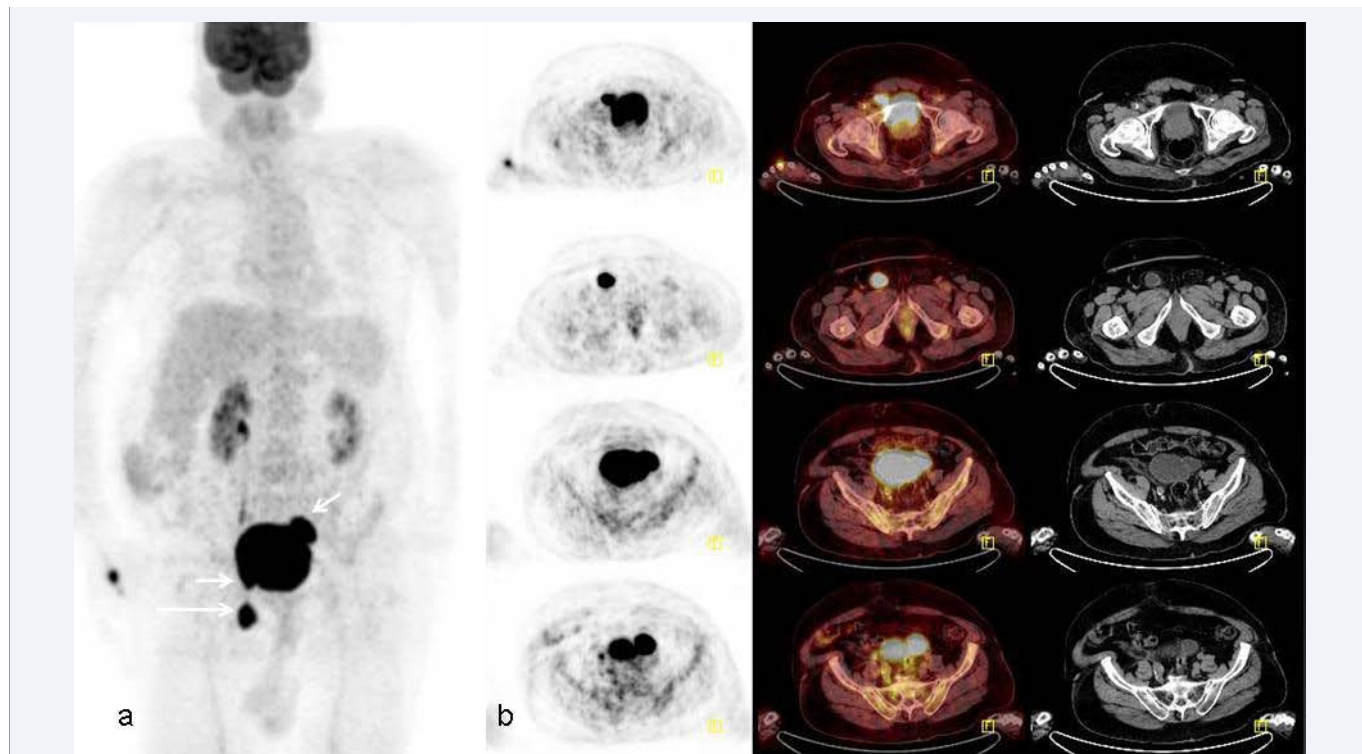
Increased FDG uptake are seen at left anterior proximal and right anterior distal areas belonging to urinary bladder diverticulum adjacent to urinary bladder at pelvic region on anterior MIP (Maximum intensity projection) image (a), and axial PET, PET/CT fusion and CT images (short arrows). Additionally, focal area of intense radiotracer uptake in left inguinal region that appears separated from the vesical activity (long arrow).
